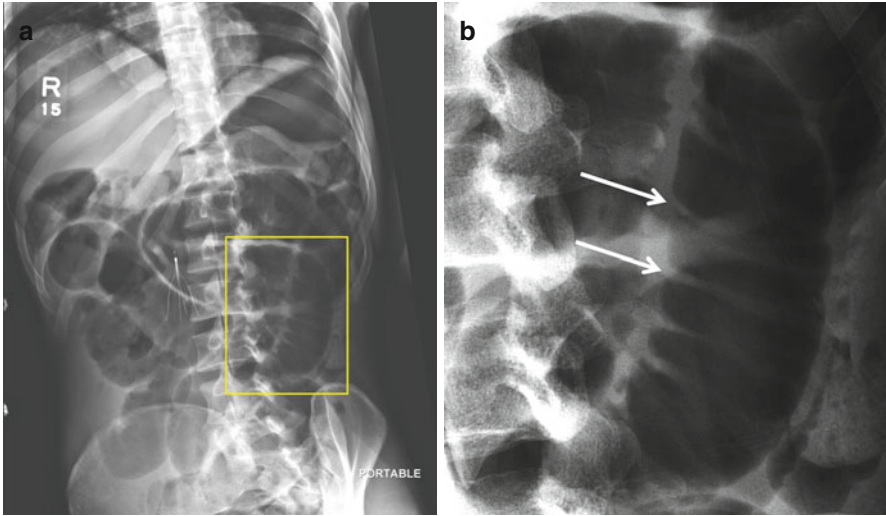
Abdominal x-ray (a) shows features of small bowel obstruction with grossly distended gas filled small bowel loops. The expanded panel (b) shows valvulae conniventes (*white arrows*) traversing the full width of the bowel loops confirming it as small bowel
